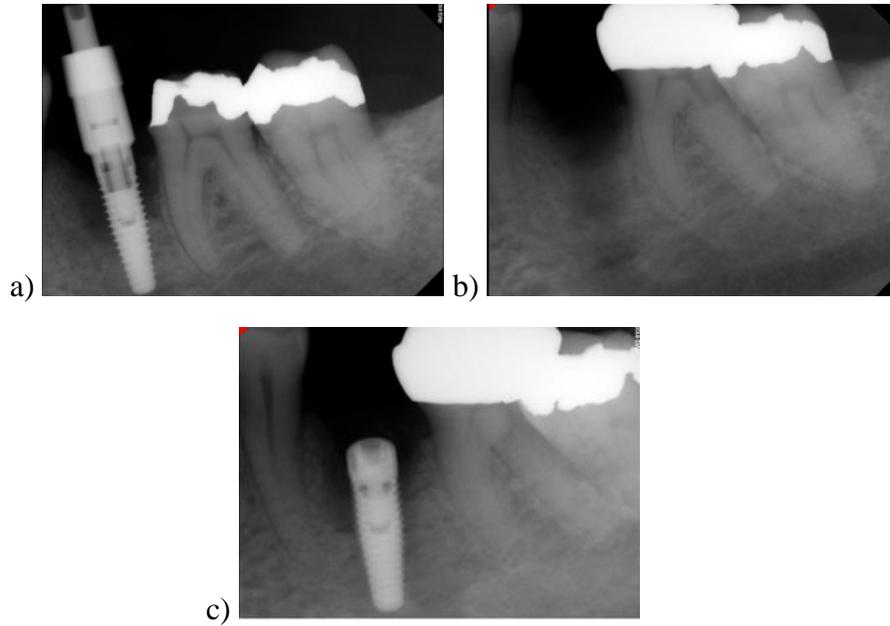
Radiographs depicting a single implant placed at the site of tooth 35 in the Dr. Gerald Niznick College of Dentistry in September 2012 (a). The implant that had a lack of osseointegration and was subsequently removed in February 2013 (b) and replaced with a new implant in January 2014 (c).
